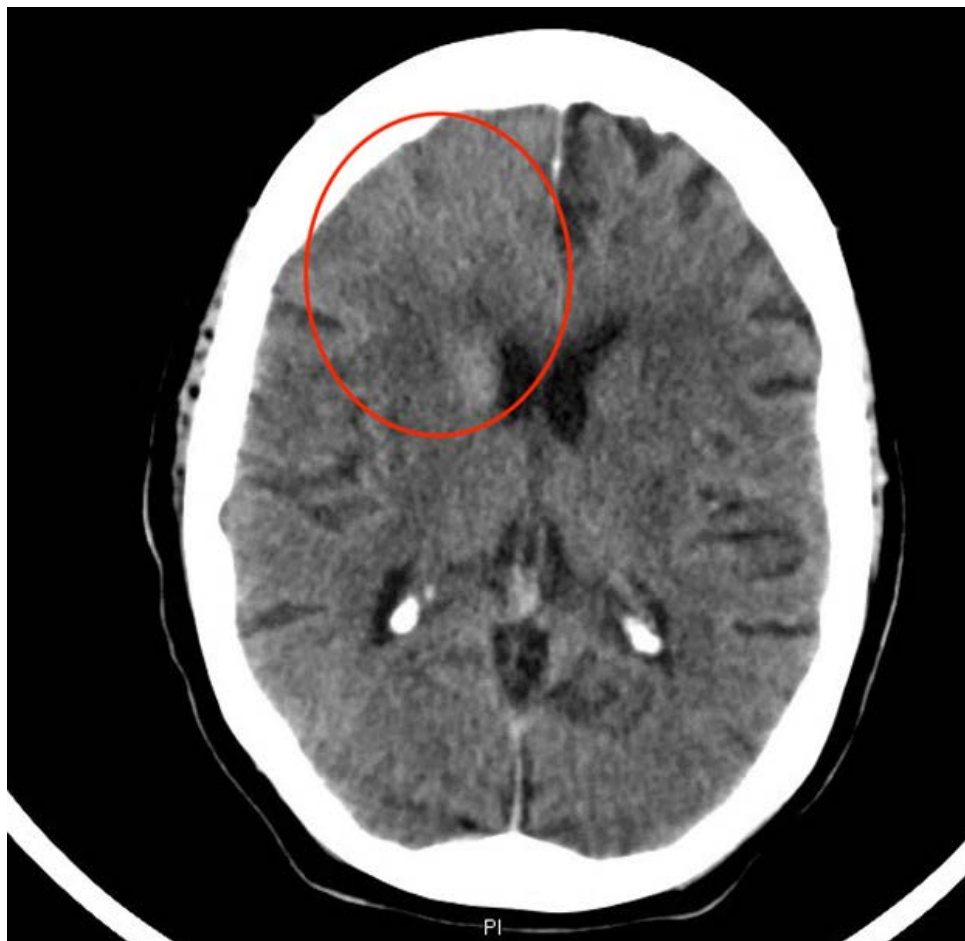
CT Brain demonstrating poor differentiation of the right frontal lobe sulci secondary to edema
